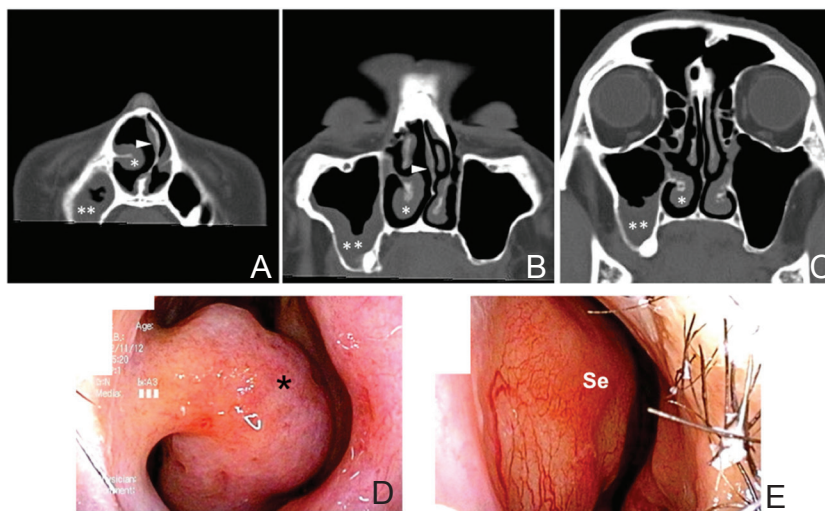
Case 2. Preoperative computed tomography (CT) scans (A–C) and outpatient endoscopic views of the right (D) and left (E) nasal cavity. CT scans reveal deviation of the nasal septum to the left and hypertrophy of the right inferior turbinate and chronic maxillary sinusitis on the right. Preoperative outpatient endoscopic evaluation confirmed narrow nasal spaces on both sides because of the hypertrophied right inferior turbinate (D) and protrusion of the nasal septum in the left nasal cavity (E). *Arrowhead*: deviated nasal septum, *asterisk*: hypertrophied right inferior turbinate, *double asterisks*: chronic sinusitis in the right maxillary sinus, *Se*: nasal septum.
